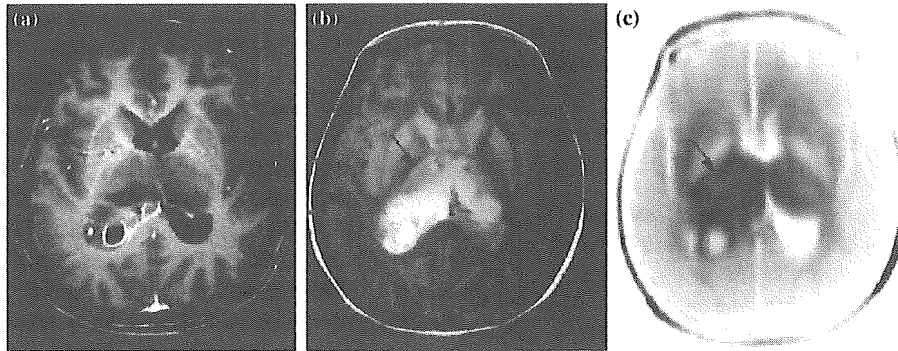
Conventional MRI and 3DAC in Case 17. (a) Gd-T1WI demonstrates glioblastoma situated in the right thalamus. (b) PDWI clearly shows the internal capsule as the tract responsible for hemiparesis, ipsilateral to the tumor (arrow). (c) Internal capsule is shown on 3DAC by absence of color change compared to contralateral side (arrow).
